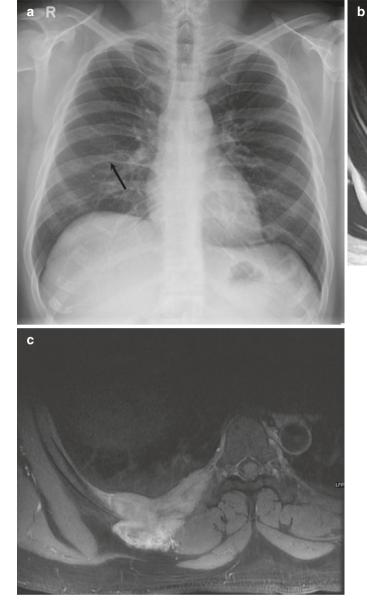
A 59-year-old man with leiomyosarcoma. (a) Frontal chest radiograph shows a destruction of the right sixth rib. (b, c) Axial CT images show a destructive lesion of the rib with large associated soft tissue
